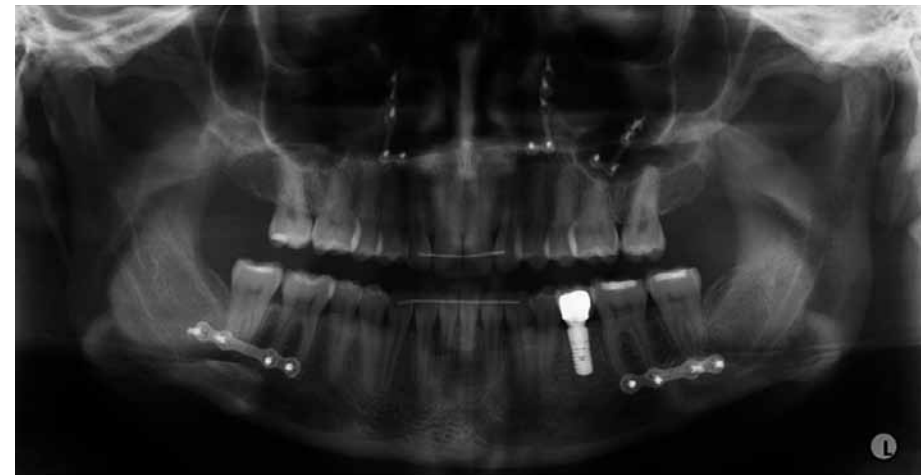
Orthopantomograph showing the position of the plates and screws in a titanium bimaxillary case. Biodegradable plates and screws in 'biodegradable-cases' were placed in a similar manner, but would not be visible on the X-ray.
